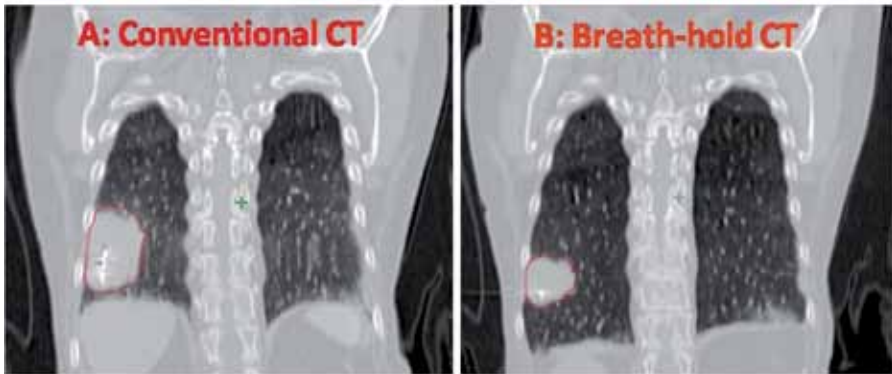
A, B: Coronal reconstructions of (A) conventional CT scan and (B) deep inspiration breath-hold CT scan for the same non-small cell lung cancer patient. Notice the distortion of the tumour in A due to motion artefacts
